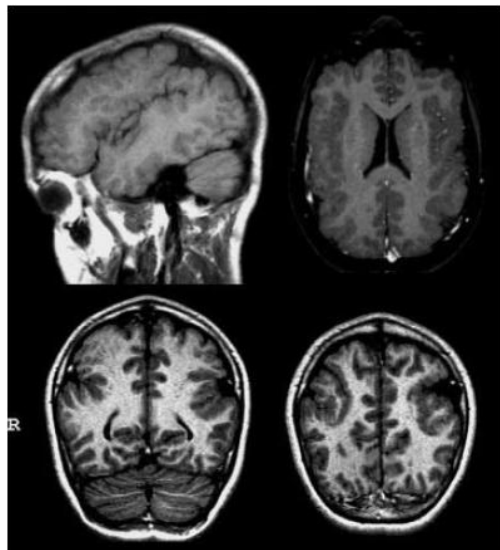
MRI from Patient III-3 (male). T1-weighted sagittal (top left), axial (top right), and coronal (bottom) images showing bilateral perisylvian polymicrogyria extending to both frontal and parietal regions.
